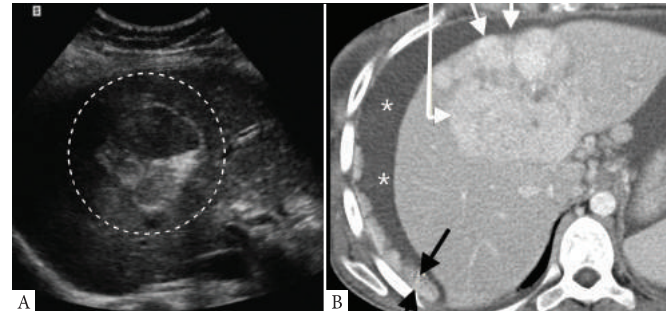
Transverse US scan through the liver: the hepatocellular adenoma (circle) has ventral isoechoic components and dorsal hyperechoic areas, the latter representing intra-tumoural haemorrhage. b. Transverse contrast-enhanced CT scan through the liver: The enhancing hepatocellular carcinoma (white arrows) is in a subcapsular location. There is peritoneal fluid (*) and peritoneal metastases are present, both indicating capsular leak.
